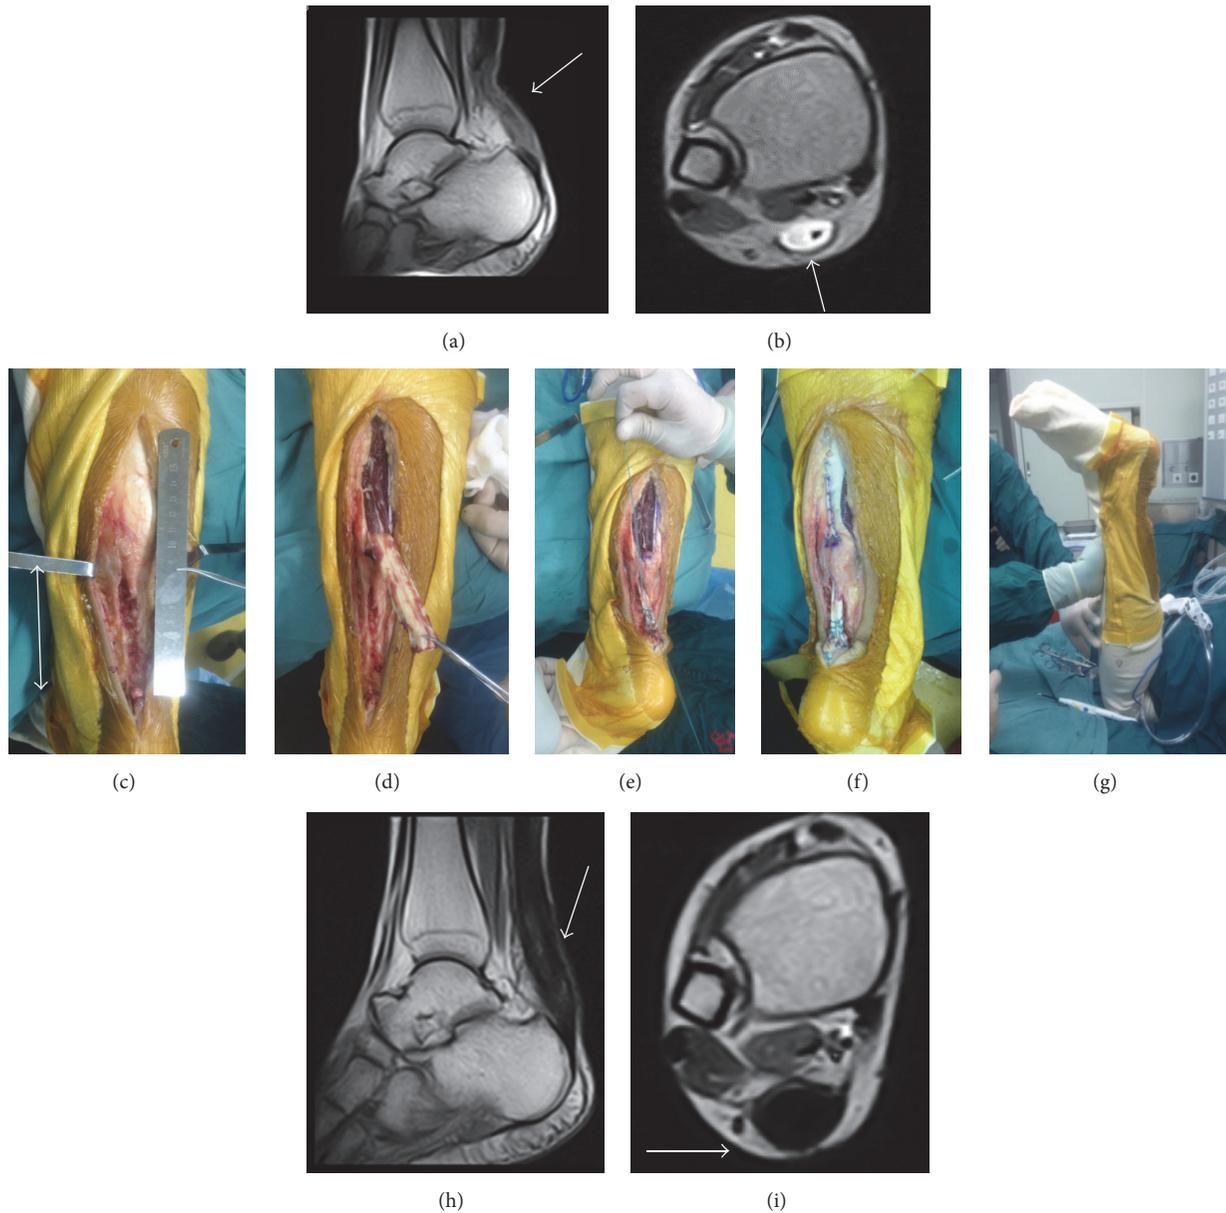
A 30-year-old male. The interval from rupture to surgery was 22 weeks. Preoperative MRI showed chronic Achilles tendon rupture (arrow) (a, b). Length of gap (double-headed arrow) was 9 cm, a lot of scar tissue located stump area, and it was difficult to perform V-Y advancement (c). Gastrocnemius fascial turndown flap performed (d, e). Sutured with the stump and adjusted the tension (f). The position of ankle was similar to the other side after surgery (g). MRI showing fusiform-shaped tendon thickening and homogeneous low-signal at 1 year postoperatively (arrow) (h, i).
